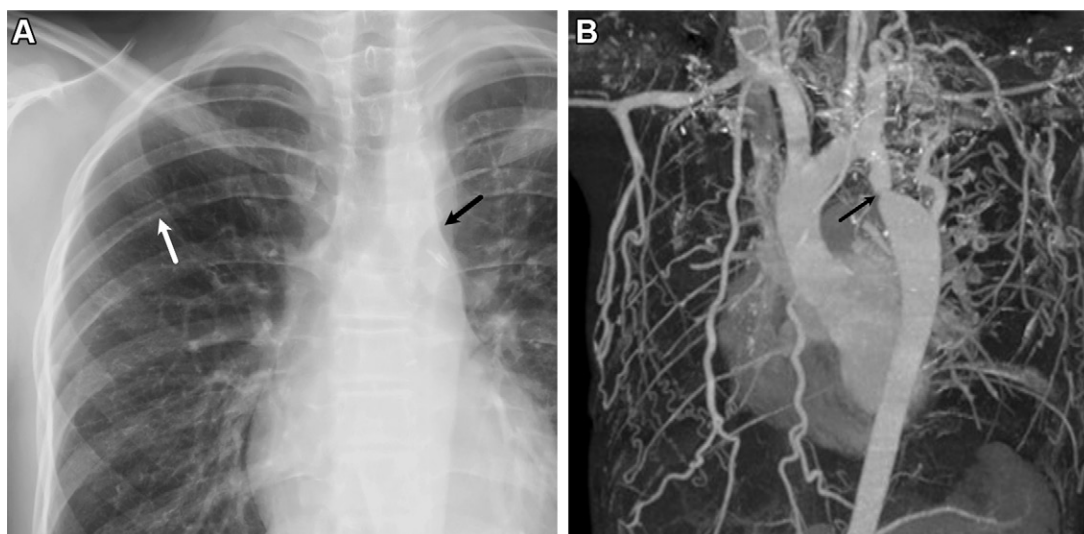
Rib notching in a 10-year-old boy with untreated aortic coarctation. (A) Frontal chest radiograph shows mild thinning with sclerosis of the inferior margin of the bilateral third to fifth posterior ribs. Focal notching is evident in the inferior margin of the right fifth rib (white arrow). The aorta shows indentation of the aortic contour (black arrow; “figure 3” sign). (B) Three-dimensional reconstruction of a coronal contrast-enhanced chest CT image shows aortic coarctation (arrow) with prominent collateral pathways including intercostal arteries.
